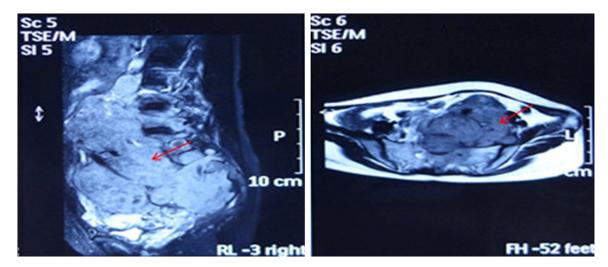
MRI scan. A large soft-tissue-mass (red arrows) in the pelvic cavity. The tumor invades the lumbosacral vertebrae and left-sided ureter.
